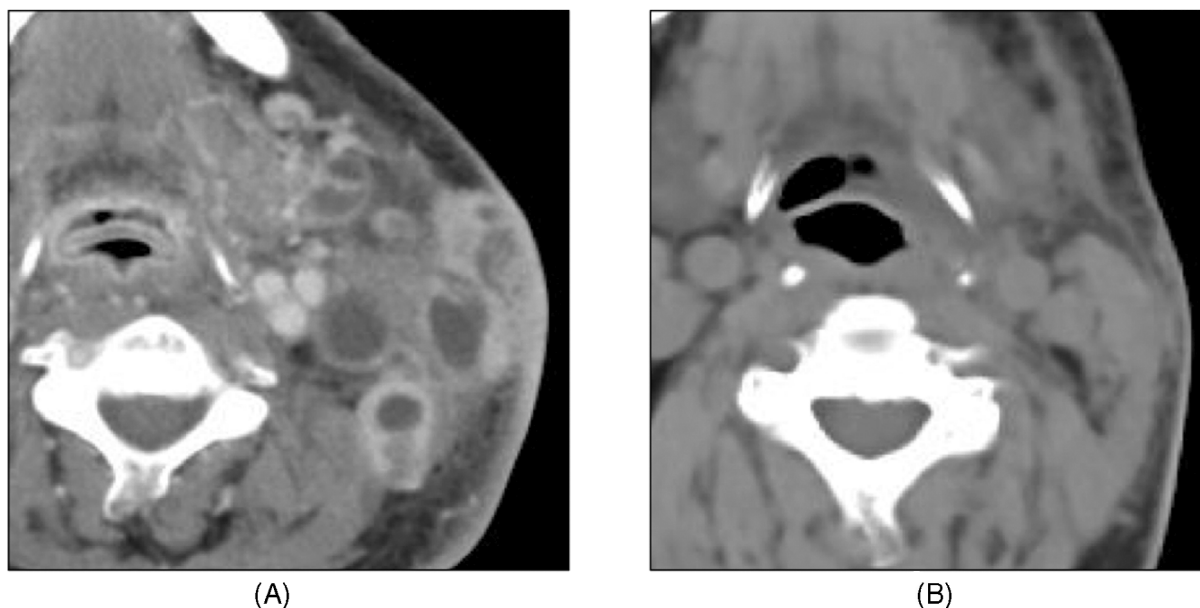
Computed tomography (CT) showing tumor disappearance of a left parotid mass and left neck metastasis in a patient with poorly differentiated carcinoma ex pleomorphic adenoma (case 9: A, B). (A) Enhanced CT of a left parotid mass and left neck metastasis before starting nivolumab. (B) Plain CT of the same lesion after administrating 11 cycles of nivolumab.
